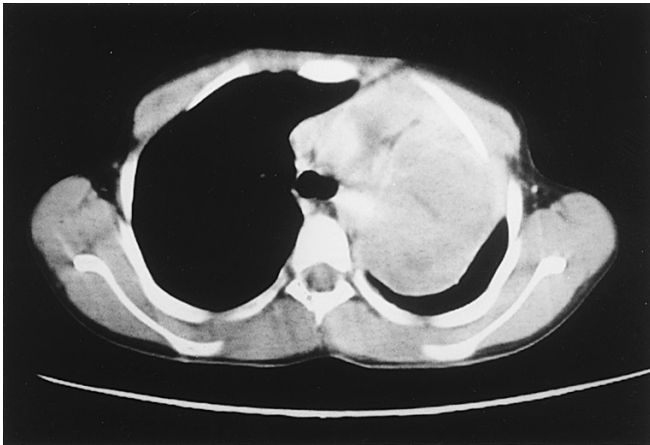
CT scan of the upper chest shows a large tumour almost completely occupying the left hemithorax
